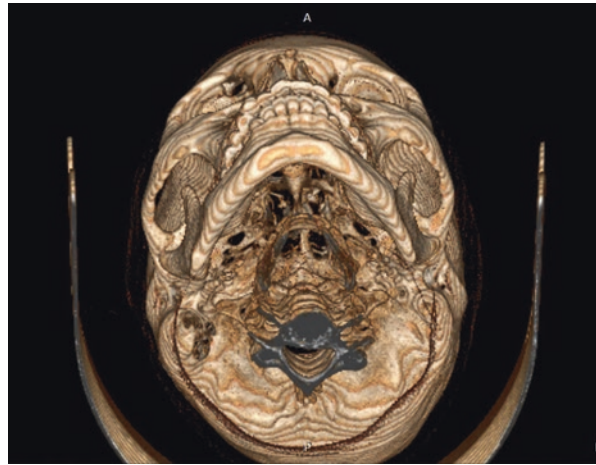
Computed Tomography (CT) image
